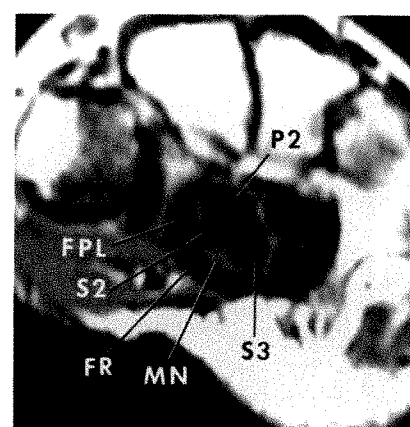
MR image (600/20) of wrist in 45° extension shows dorsal shifting of flexor tendons relative to neutral and anterior positioning of median nerve. Both anterior and interposed neutral nerves assume this position on extension. (See key for abbreviations.)
